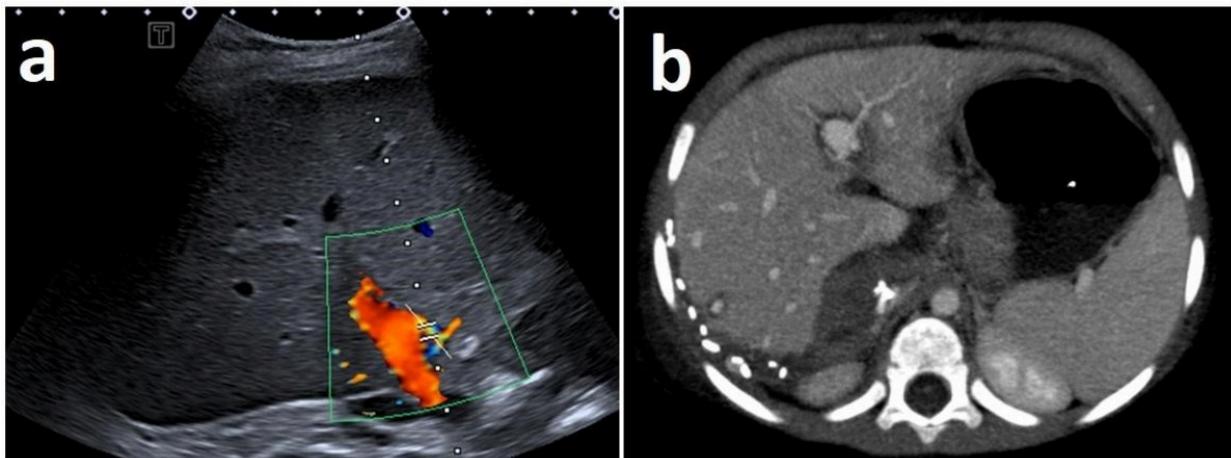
Types of transplants: a) Total Liver Transplant seen by ultrasonography from a transverse right upper quadrant vision; b) Partial Liver Transplant seen in a CT axial reformation, notice the multiple surgical staples in the hepatic graft edge.
